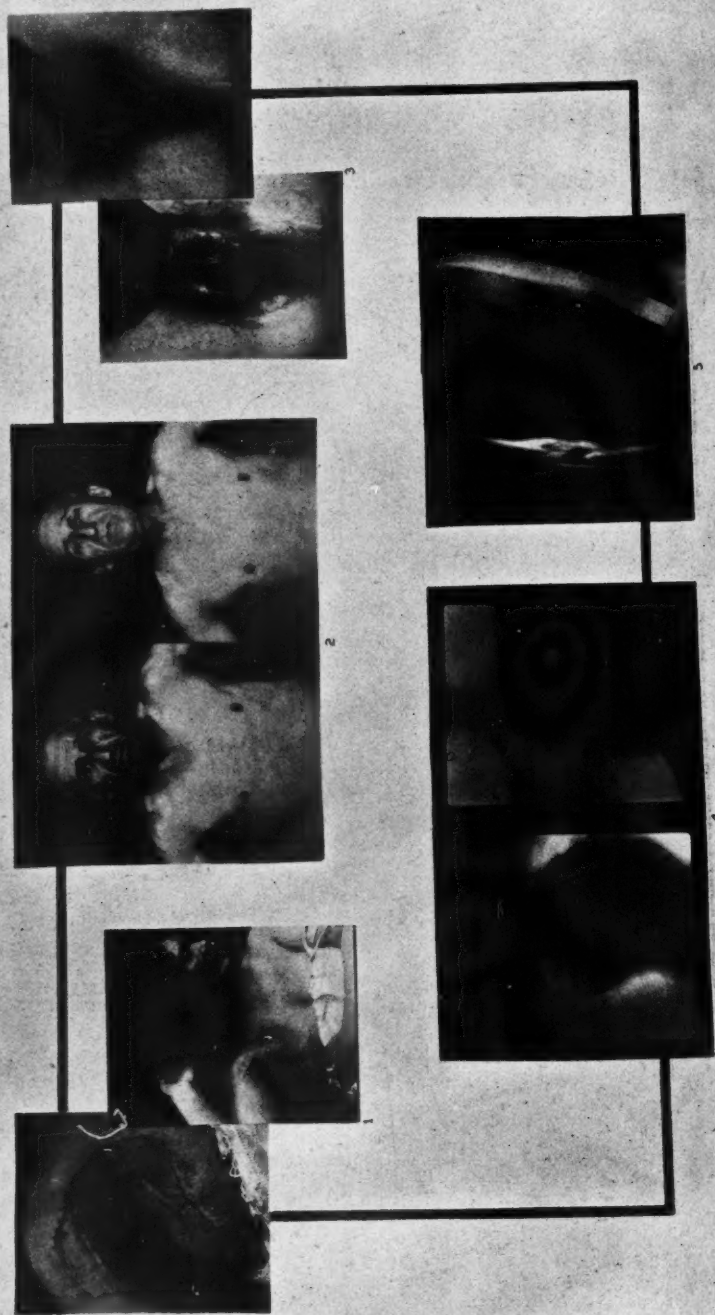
(1) Post-operative recurrent carcinoma of the breast before and after treatment with X-rays. (2) Generalized Hodgkin's disease before and after treatment with X-rays. (3) Condyloma of the vulva before and after treatment with X-rays. (4) Lymphosarcoma of the chest before and after treatment with X-rays. (5) Bone sarcoma before and after treatment with X-rays.
